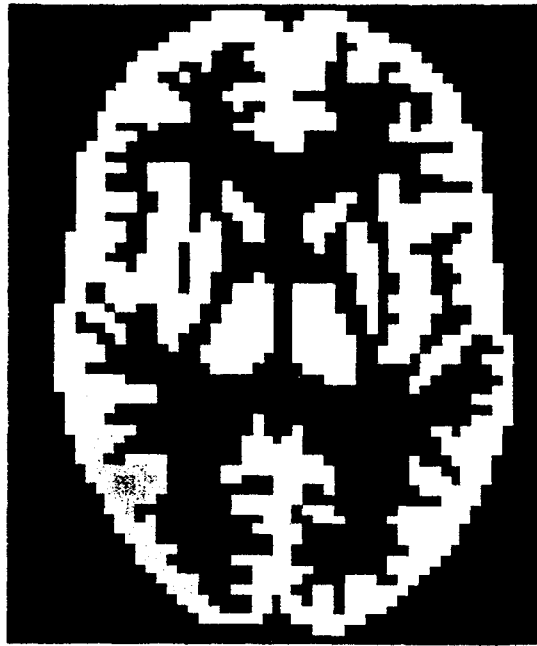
Digitized mathematical brain model at the level of basal ganglia chosen from the three dimensional Hoffman brain model. The model was derived from MRI images, anatomy atlases, and the knowledge of anatomy and FDG distributions in the brain.
